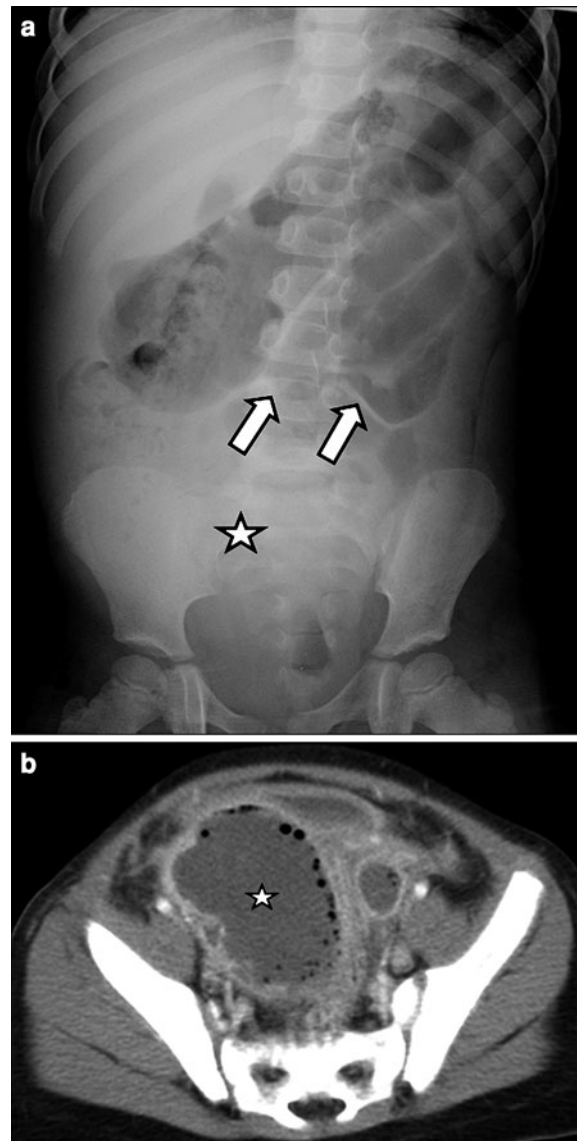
Three-year-old girl with periappendiceal abscess due to perforated appendicitis. Supine abdominal radiograph a shows faint soft tissue density (*star*) in the right lower quadrant with subtle mass-effect (*arrows*) over the loops of small bowel. Post-contrast axial CT image b shows a large abscess formation (*star*) in the right lower quadrant with surrounding inflammatory changes
